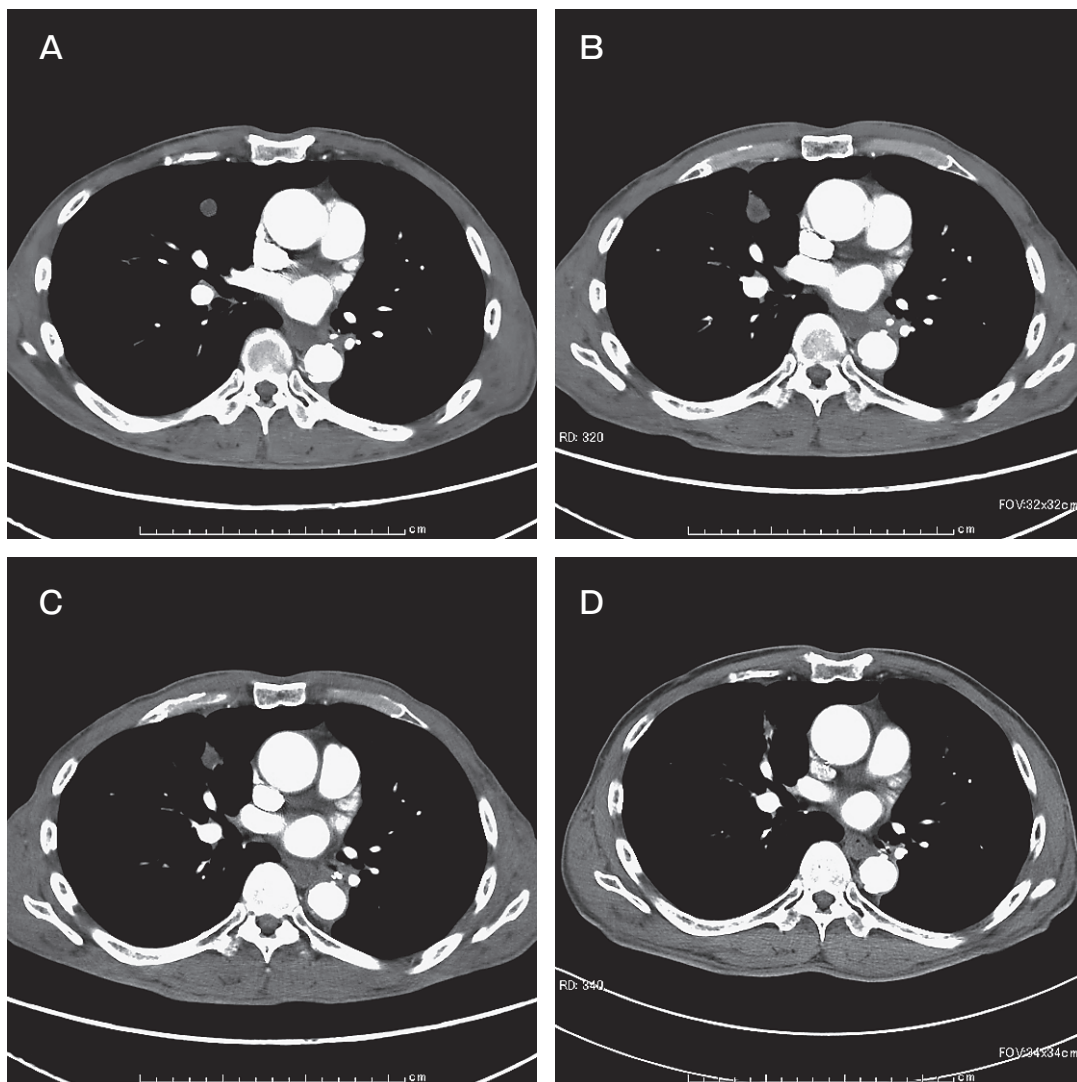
CT images after pulmonary RFA in patients with metastatic tumor from rectal carcinoma. A, Pre-RFA CT of 62-year-old male with pulmonary metastatic tumor in the right upper lobe; B, C, D The follow-up CT examination showed the dimension of tumor had enlarged at 3 months after RFA(B). The dimension of tumor had gradually shrunk during the first 24 months after RFA. At 6 month- and 24 month-after ablation, there was the vessels enhancement at the peripheral of the ablated lesion; however CT showed no irregular enhancement within the ablated lesions (C, D). There was no tumor enlargement with contrast enhancement at each time points.
